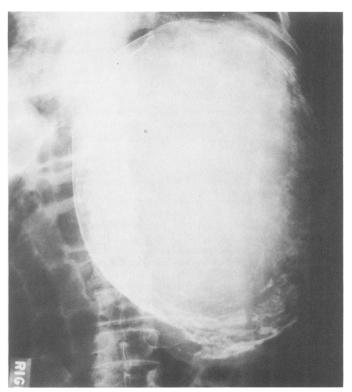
Abdominal roentgenogram showing huge calcified echinococcal cyst of the spleen.
